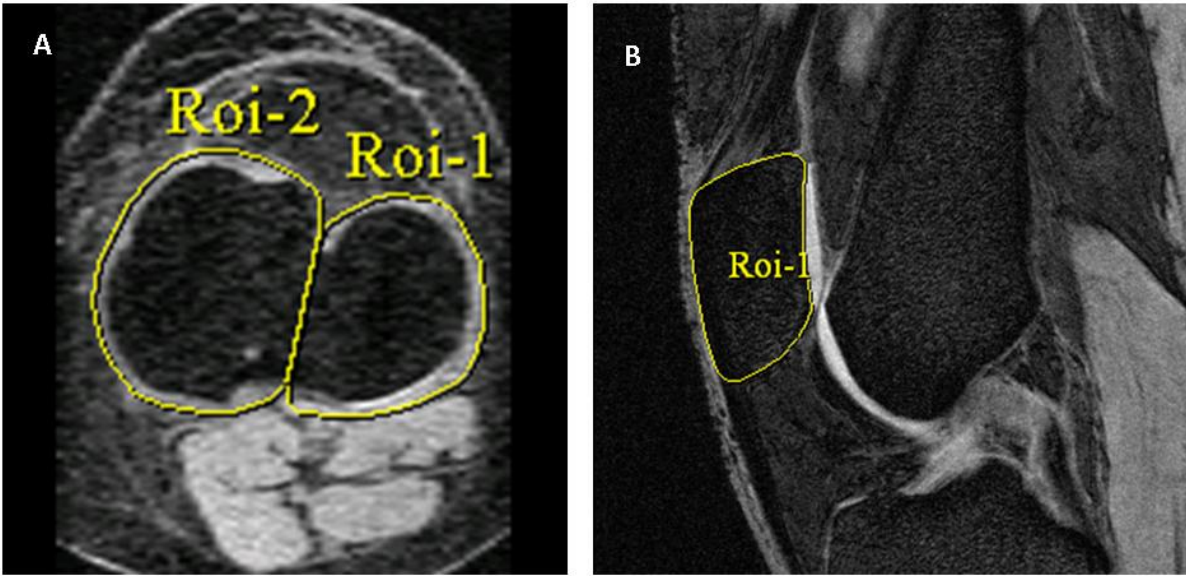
MRI images showing the regions used to calculate A) tibial plateau bone area, and B) patella bone volume.
